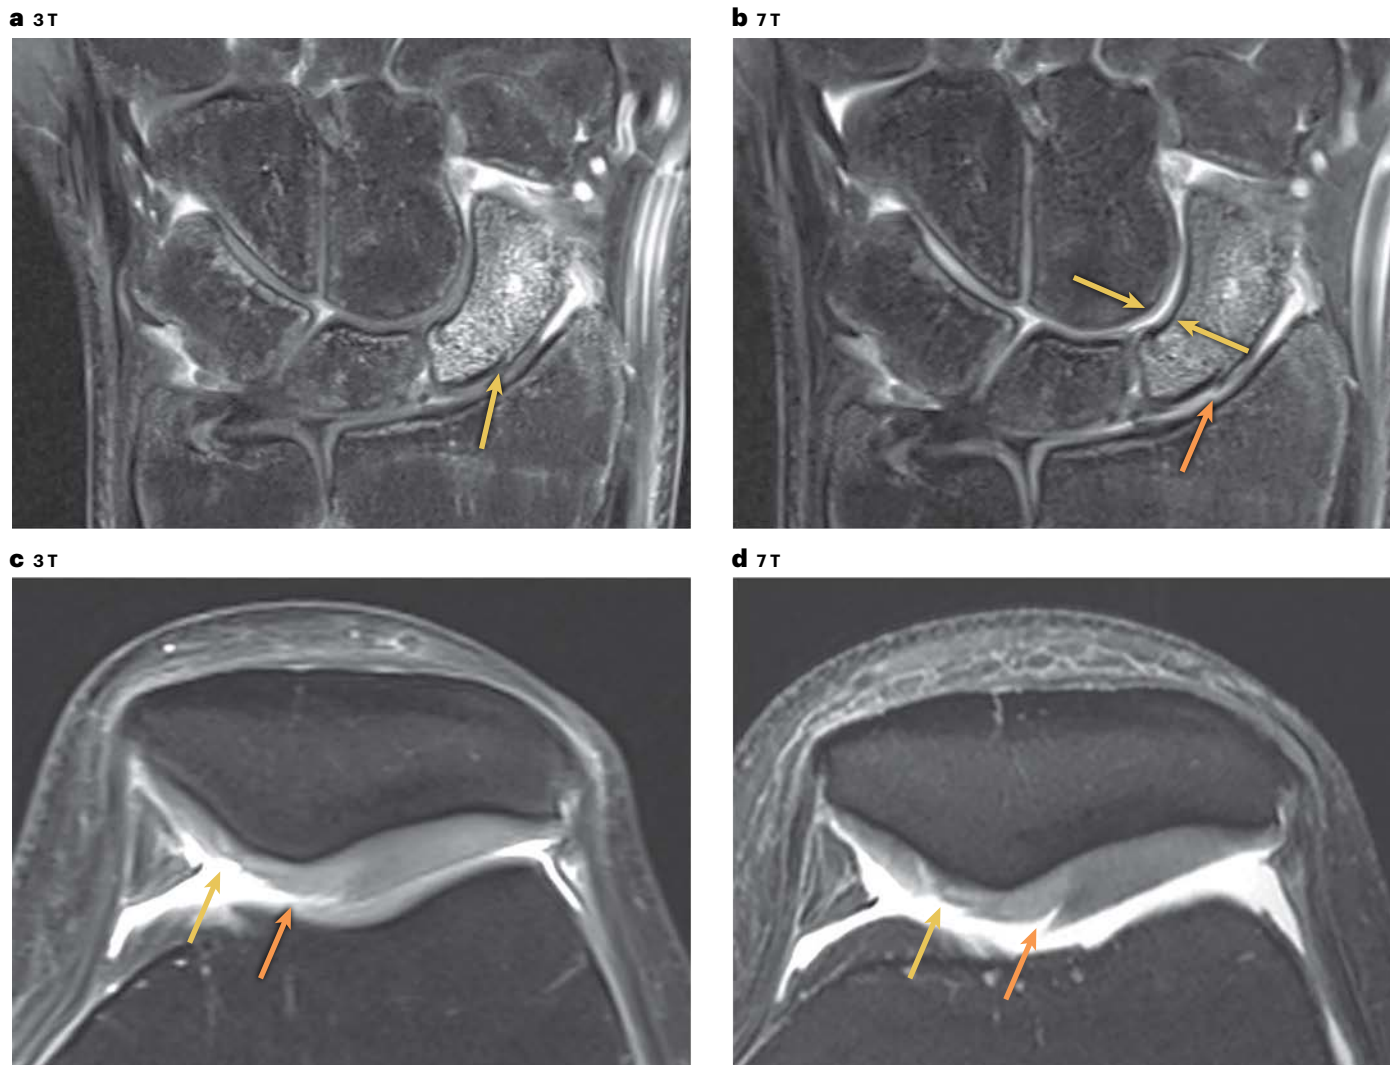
Direct comparison between 3 T and 7 T MRI. Increased field strength can be used for acceleration of image acquisition or increase in spatial resolution. a, 3 T MRI (coronal intermediate fat-suppressed image) shows a scaphoid fracture with marked bone contusion and a small step-off of the proximal cortex. The proximal fracture location is depicted by the yellow arrow. It is unclear whether the cartilage surface is intact or not. b, Corresponding coronal 7 T image similarly shows a definitive small step-off of the proximal articular surface (orange arrow). In addition, superior delineation of the capitae and scaphoid cartilaginous surfaces occurs at 7 T compared with 3 T (yellow arrows), probably
